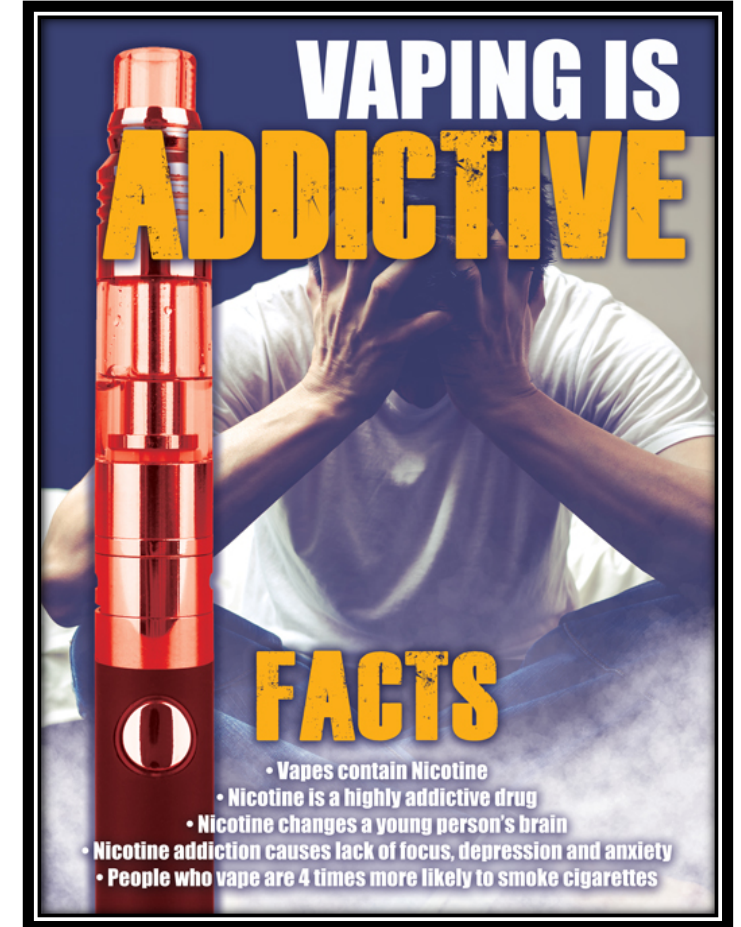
CT Clearinghouse Poster
